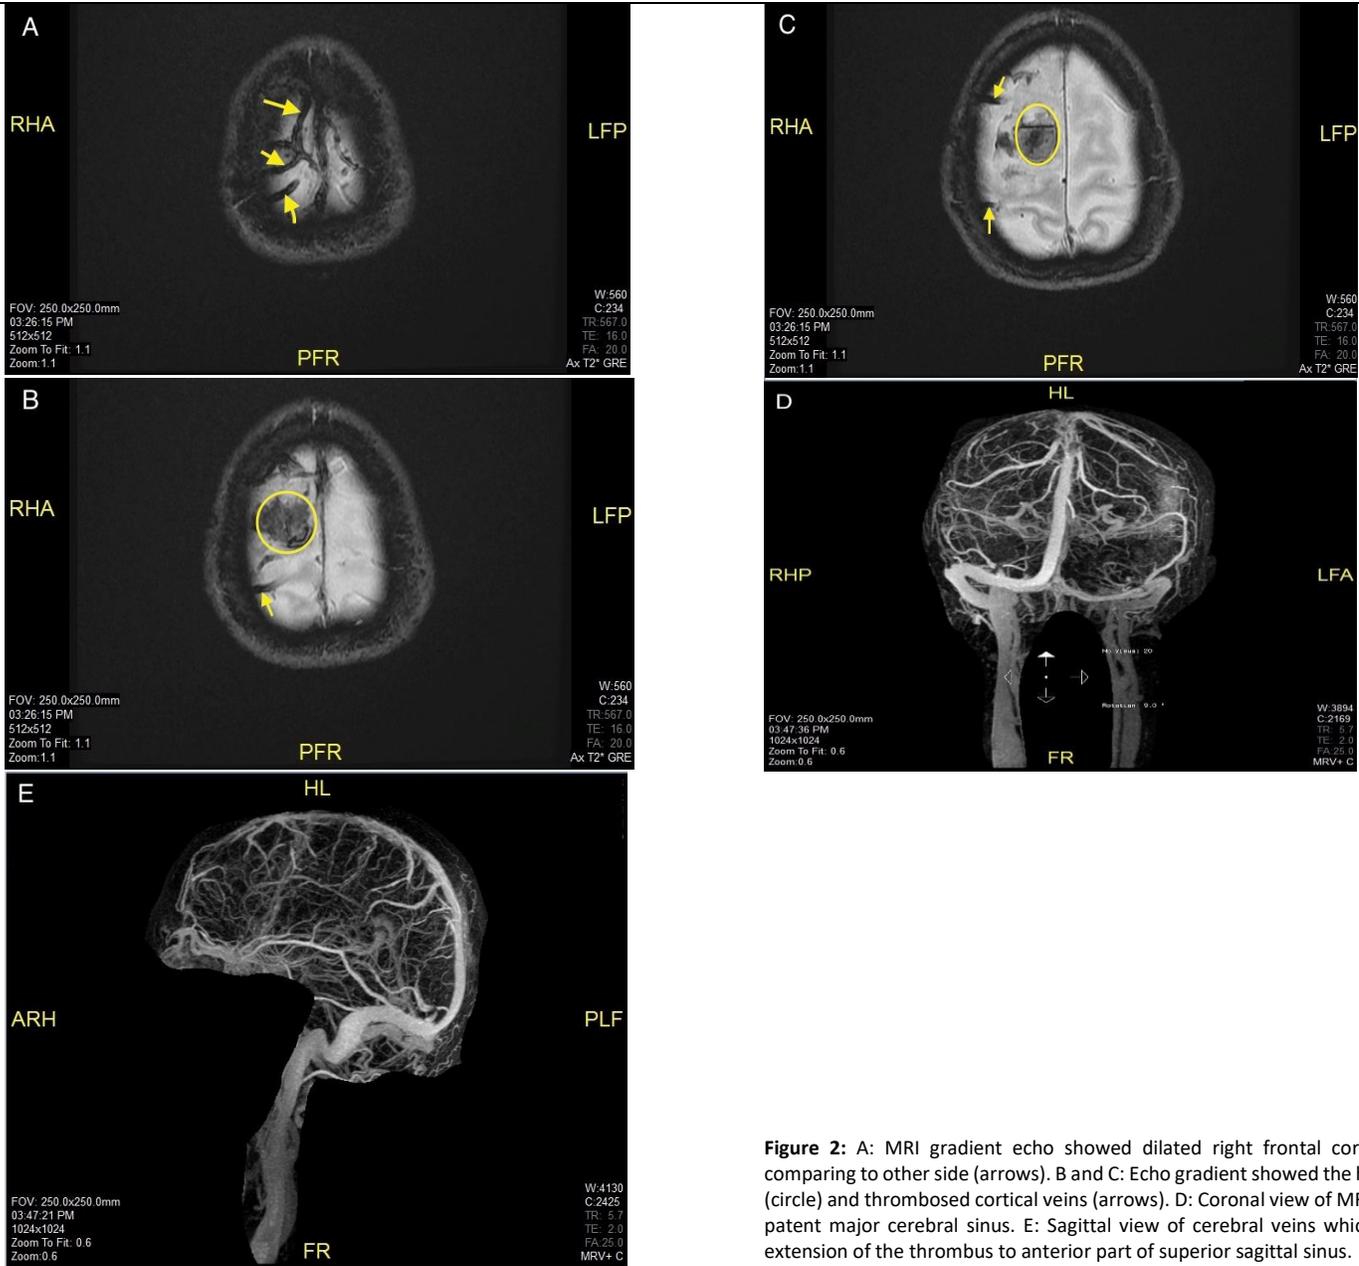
A: MRI gradient echo showed dilated right frontal cortical veins comparing to other side (arrows). B and C: Echo gradient showed the hematoma (circle) and thrombosed cortical veins (arrows). D: Coronal view of MRV showed patent major cerebral sinus. E: Sagittal view of cerebral veins which showed extension of the thrombus to anterior part of superior sagittal sinus.
